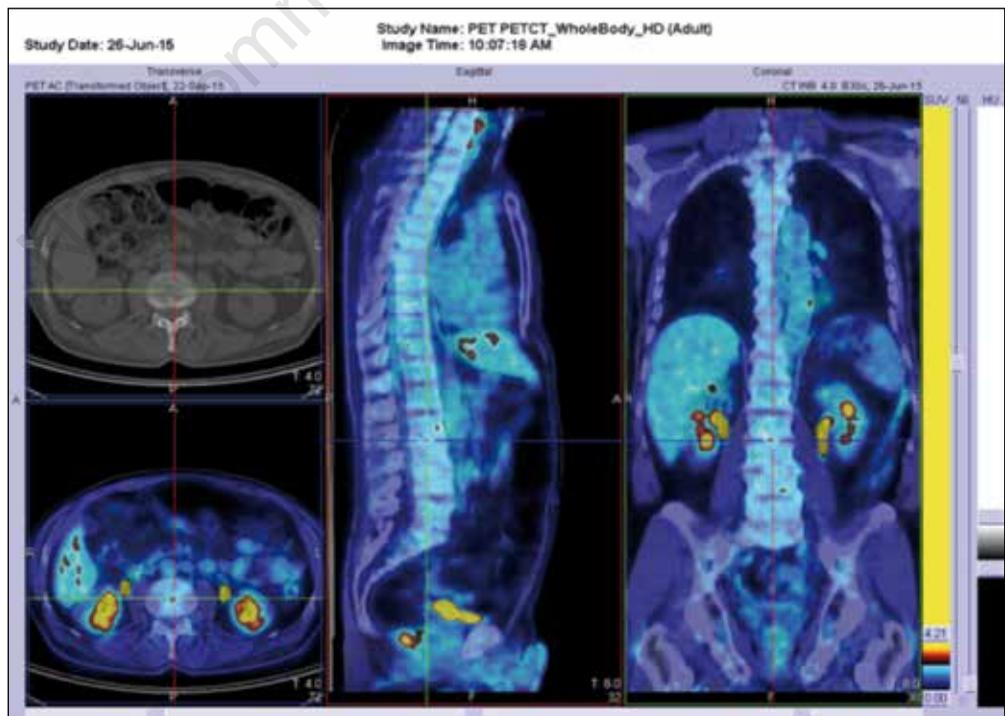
18F-FDG-PET/CT after six months of treatment repeat testing showed no uptake of the discs and vertebral bodies.
